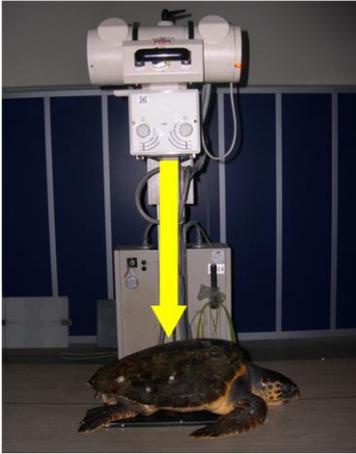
Positioning the patient to perform radiographic exam in dorsal-ventral projection with vertical x-ray beam.
